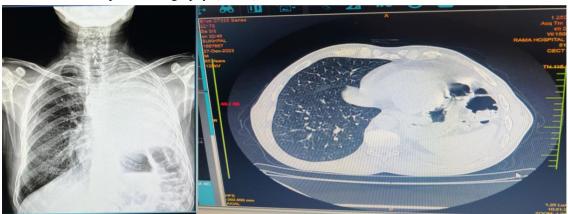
Chest X-ray (CXR) showing air space consolidation involving the left mid and lower zones. Figure 10: Contrast-enhanced computed tomography (CECT) of the chest demonstrating air space consolidation in the left upper and lower lobes, accompanied by mediastinal lymphadenopathy.
